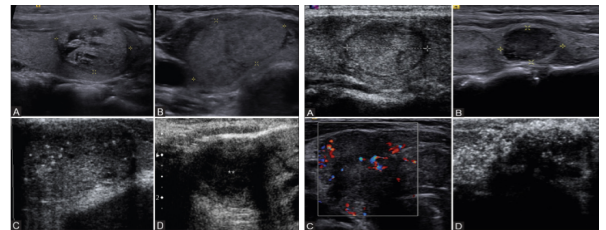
Ultrasound image showing A. Hyperechoic B. isoechoic C. hypoechoic and D. markedly hypoechoic thyroid nodules
